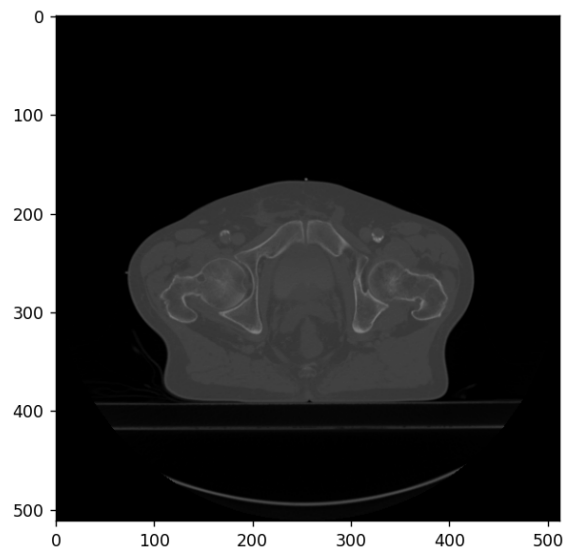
CT scan of the hip and femoral joint
